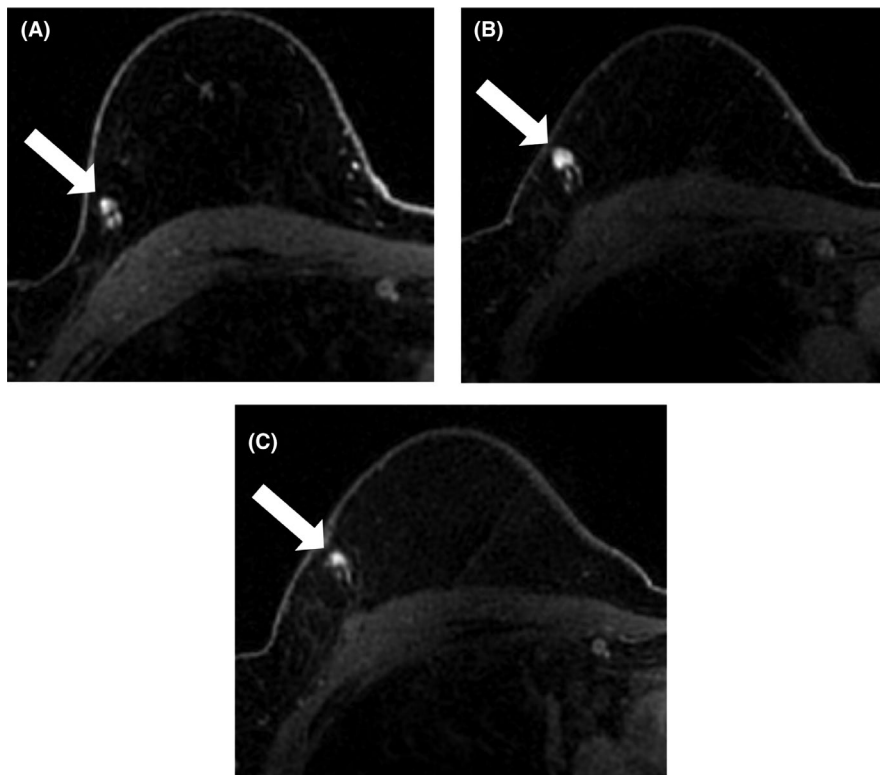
Change in morphology of LNs: 48-y-old woman with a normal appearing intramammary LN on preoperative T1-weighted contrast enhanced image (A), presenting with enlargement on postoperative MRI (B). Follow-up MRI (C) 2 y later showed that the LN returned to its preoperative dimensions
